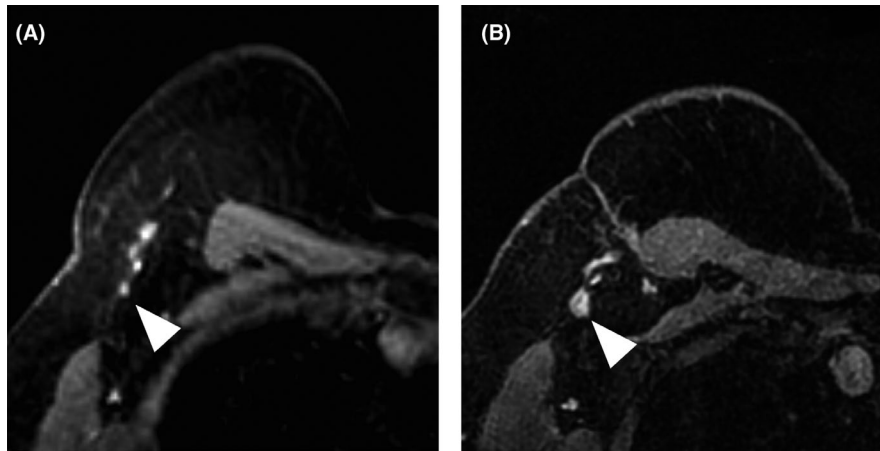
Change in morphology of LNs: T1-weighted contrast enhanced images showing a 45-y-old woman with a small axillary LN on preoperative MRI (A) with enlargement on postoperative MRI (B, arrowheads)
